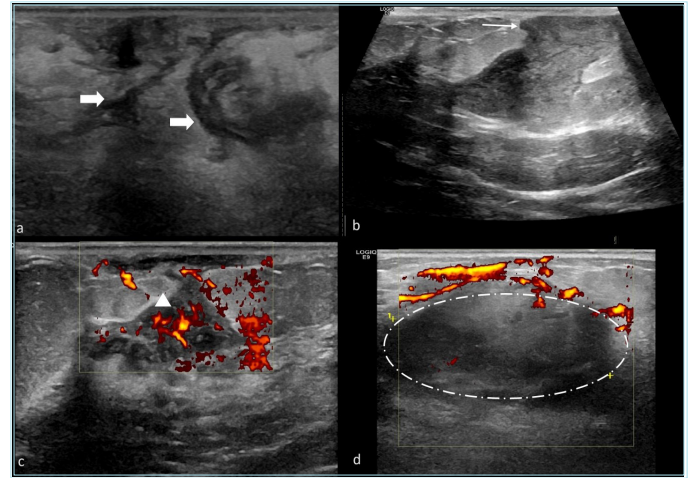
Ultrasonographic images from three different patients diagnosed with idiopathic granulomatous mastitis. The first image (a) shows irregular hypoechoic lesions interconnected by tubular extensions (arrows) and increased echogenicity of fat tissue due to inflammation. The images (b) and (c) display polygonal-shaped irregular hypoechoic lesions with vascularization on doppler imaging (arrowhead), extending towards the skin (thin arrow). The image (d) shows a hypoechoic round abscess focus (circled) with peripheral vascularization in the advanced stages of the disease
